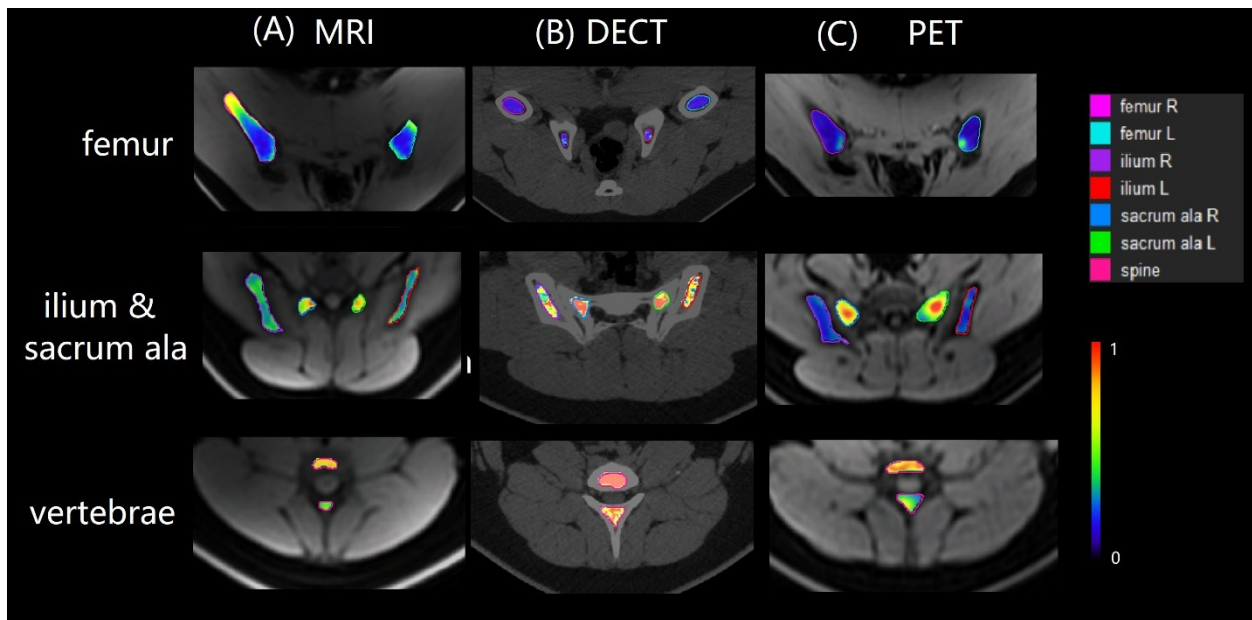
Color-wash images of active marrow volume fraction computed from (A) water-fat MR, (B) DECT decomposition, (C) PET. The color-wash images were fused to (A) water MRI, (B) high-energy CT, (C) MRI acquired from PET/MR. The PET was normalized by the maximal PET signal within the bone marrow. The colors of structure contours are shown in the legend.
